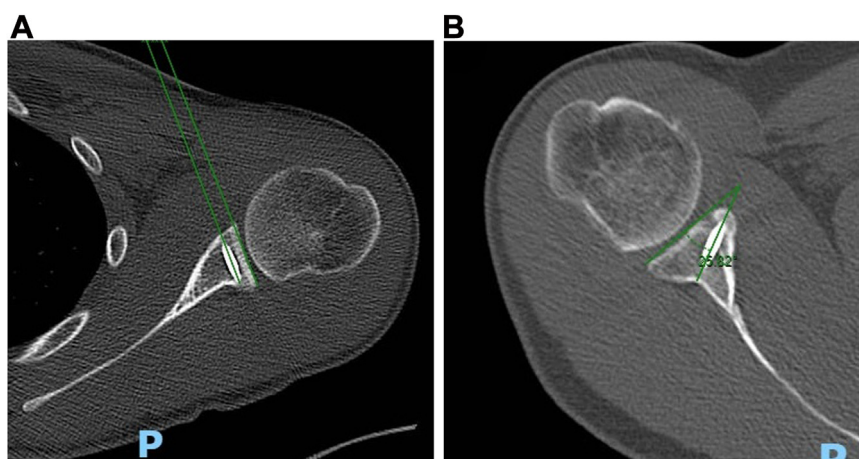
(A) Axial view of the right shoulder in a postoperative CT scan showing unicortical screw and 0° α angle (parallel to subchondral bone glenoid). (B) Axial view of the right shoulder in a postoperative CT scan showing bicortical 25.8° α angle screw toward the glenoid vault. CT, computed tomography.
